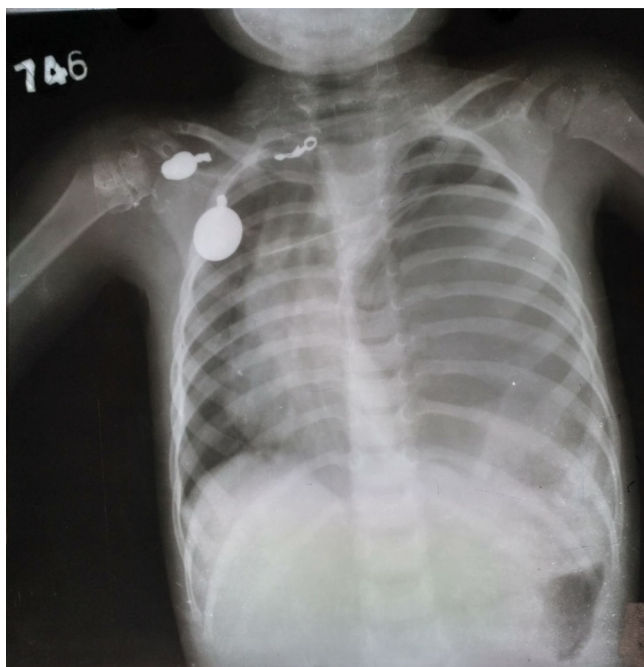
Chest X-Ray showing large rounded homogenous opacity along with air filled gut loops in left hemi-thorax compressing the left lung to left apical region and mediastinal shift to contralateral side resulting in a compressed right lung.
